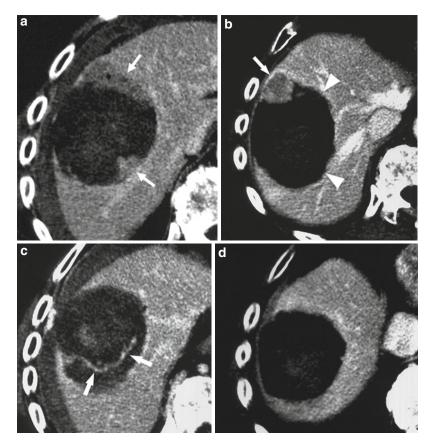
Increased tumor destruction with combined RF and liposomal doxorubicin. An 82-year-old male with an 8.2 cm vascular hepatoma. (a) CT image obtained immediately following RF ablation shows persistent regions of residual untreated tumor (*white arrows; black zone* = ablated region). (b) Two weeks following therapy, there is interval increase in coagulation as the 1.5 cm inferior region of residual tumor and the 1.2 cm anteromedial portion of the tumor no longer enhance (*white arrowheads*). A persistent nodule of viable tumor is identified
